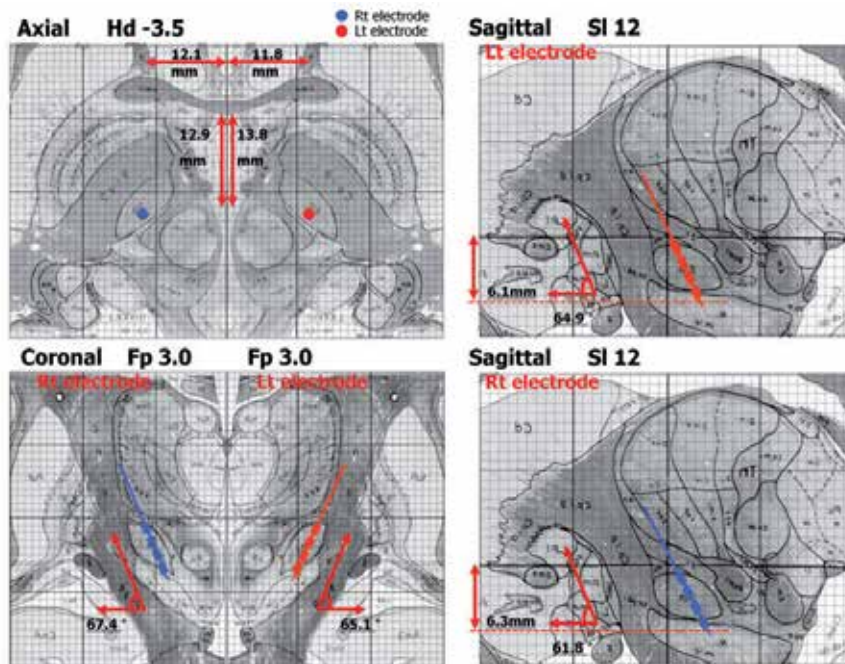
Electrode positions plotted with reference to the human brain atlas of Schaltenbrandt and Wahren. The electrode positions are based on information obtained from fused images of preoperative MRI and postoperative CT taken one month after surgery.
